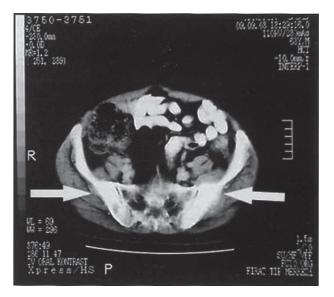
Pelvic CT demonstrates metastatic involvement on the iliac bones (*arrows*), significantly on the left.
